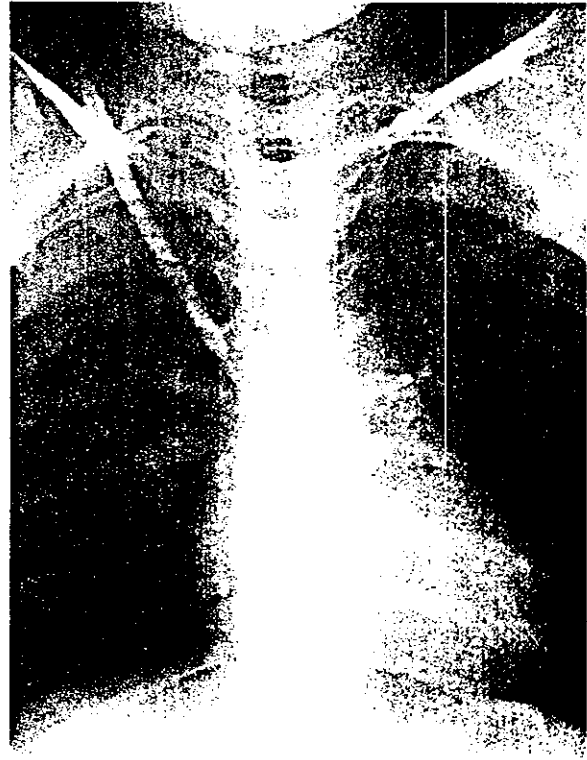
Radiograph after two courses of irinotecan. Marked reduction in tumor size.
